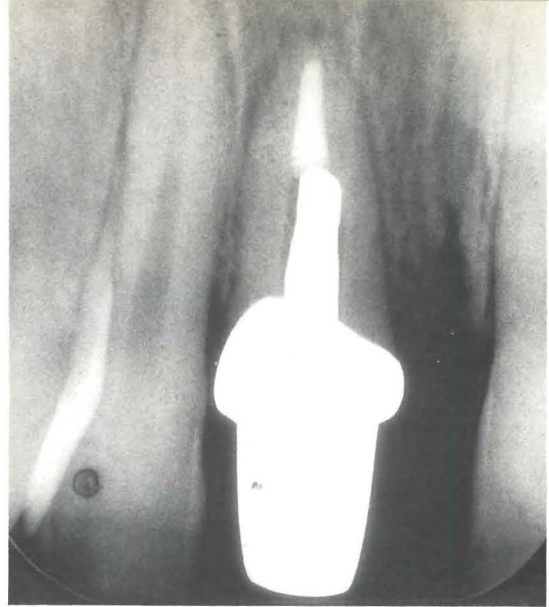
The radiographic situation at cementation of the restoration.
